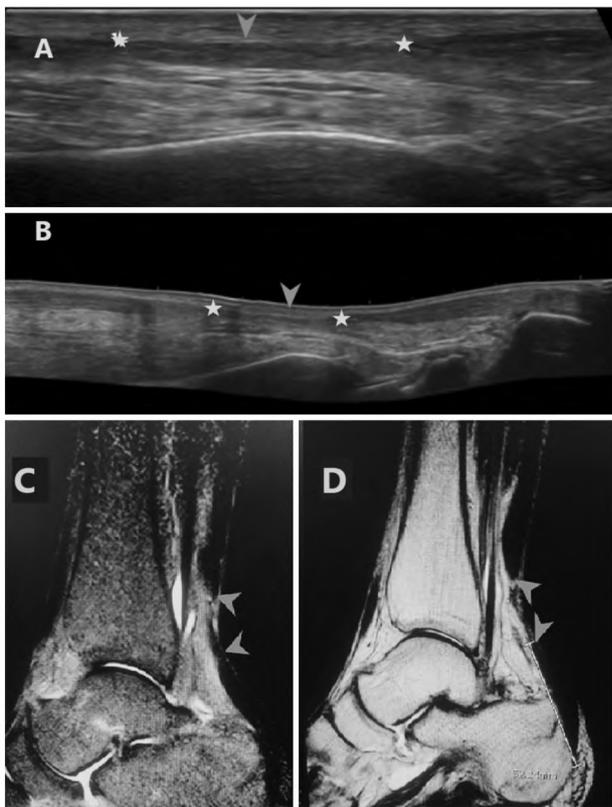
Longitudinal (A) and panoramic (B) views of AT in A 40 years old male patient complains of acute ankle pain after twisting his ankle accidentally, AT showing full thickness tear of the mid segment (stars) with gapping (arrows), the cut edges are thickened with hypo-echoic texture. MRI, STIR-Sagittal (C) and T2WI sagittal (D) showing full thickness tear of the AT with gapping (arrows).
